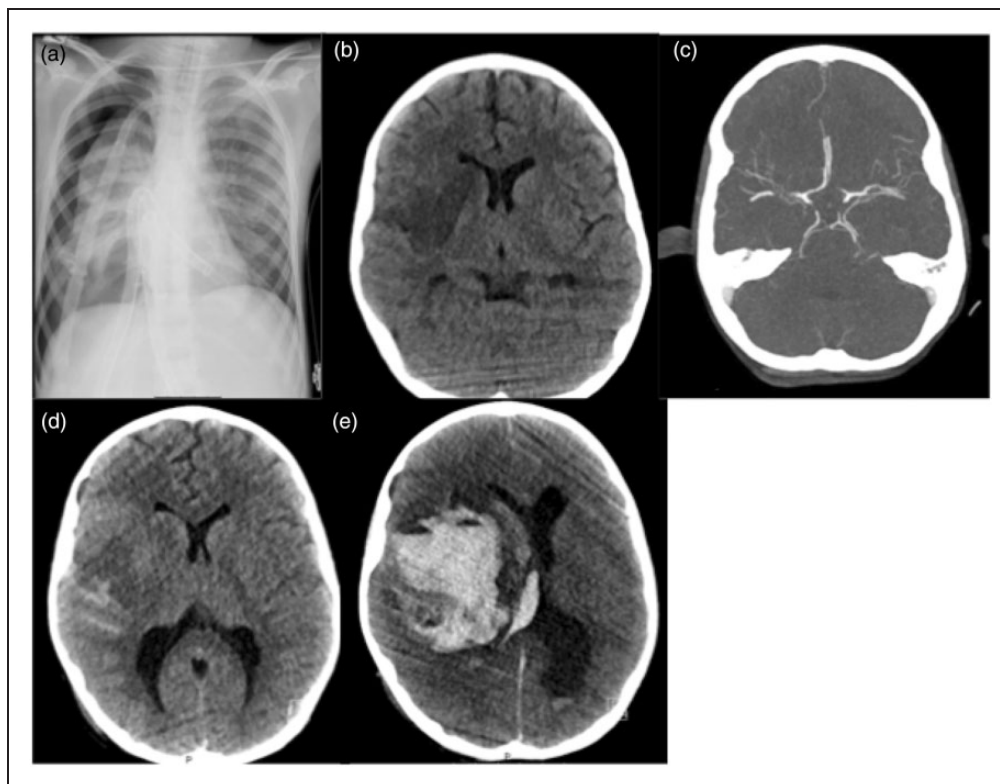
An 8 year-old child under external left ventricular assist device, as shown on a plain chest x-ray (a), under sedation and ventilated, had an unknown onset of left hemiparesis. Head CT scan showed an already established acute ischemic lesion affecting the perforator and superior division of the right MCA (b). CT angiogram showed a proximal M1 occlusion, with good collaterals (c). Considering that thrombectomy was the only alternative of treatment, and that only part of the MCA territory was infarcted, a decision to treat was made, and complete recanalization was obtained. CT at 24 h showed the same ischemic lesion, and slight subarachnoid haemorrhage (d). The patient was kept under sedation. At 10 days post thrombectomy, the patient developed sudden signs of intracranial hypertension, and assymmetric pupils. Emergent CT showed massive hemorrhagic transformation of the ischemic lesion (e), and the patient did not survive.
